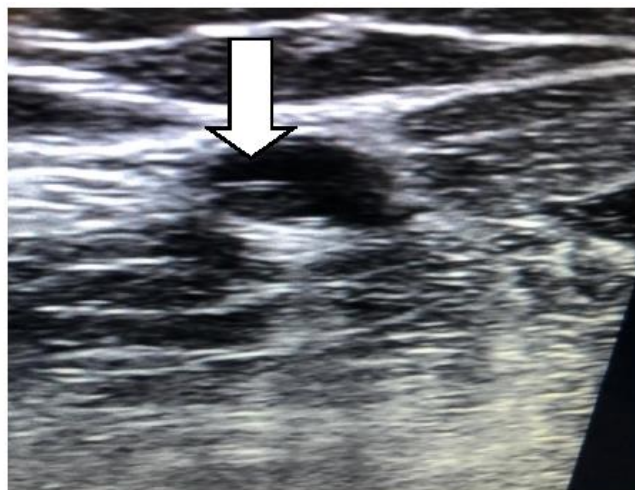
A view of basilic vein (white arrow depicts PICC line) through ultrasound guidance
